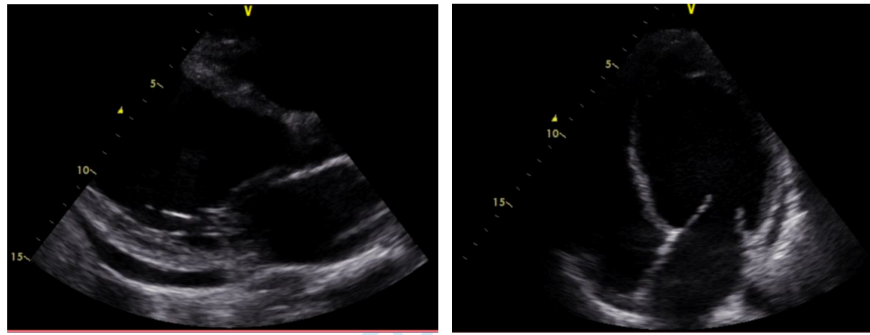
Bedside echocardiogram showing a parasternal long-axis view on the left and an apical four-chamber view on the right at ICU admission.
